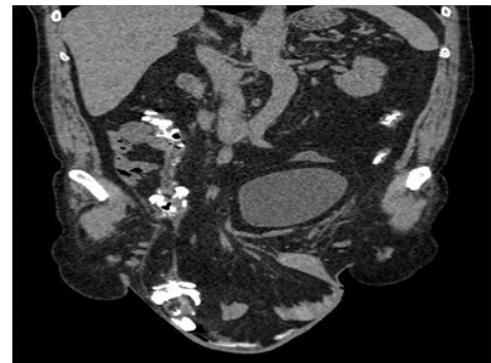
Coronal CT scan.
